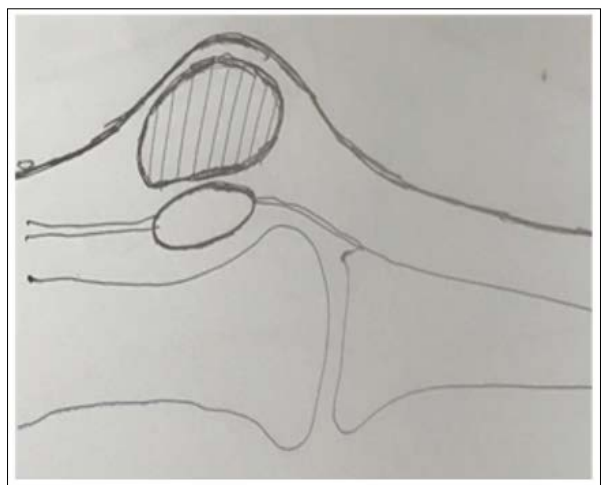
X-rays and MRI showed severe contracture of Rectus Femoris; Patella alta 3 cm higher than normal position. Not much intraarticular adhesions. Patellofemoral articulation smooth. The axes well aligned, only slightly recurvated
